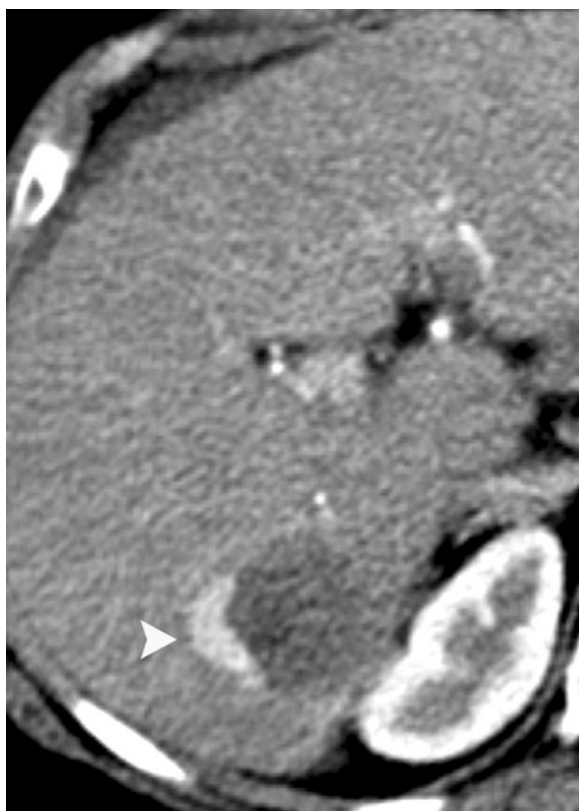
Recurrence of HCC with halo pattern in the posterior segment of the right hepatic lobe previously treated with ablation. The CT scan at the arterial phase after intravenous contrast administration shows a peripheral halo-shaped enhancement (*arrowhead*) indicating the presence of residual viable tumor.
